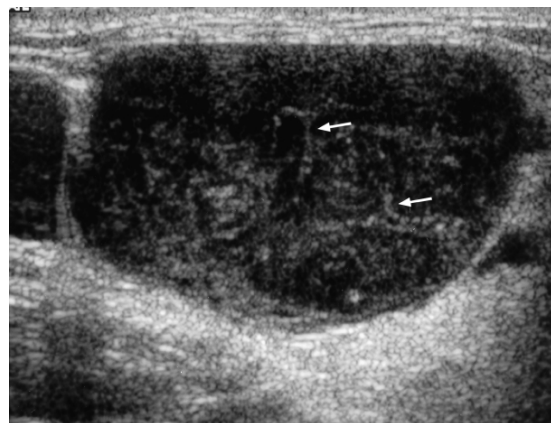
Sonogram showing a lymphomatous node with intranodal reticulation (micronodular pattern) (arrows).
